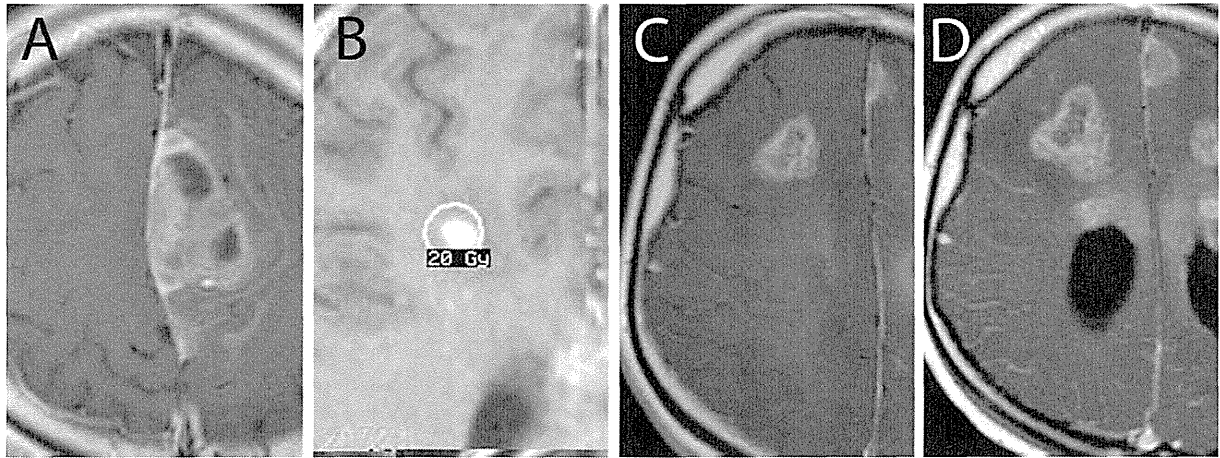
Case 7 in Table 1 is shown: (A) axial gadolinium-enhanced T1-weighted magnetic resonance imaging (MRI) at presentation; (B) dose planning of stereotactic radiosurgery for recurrence; (C, D) MRI taken at 1 (C) and 3 months (D) after stereotactic radiosurgery showing tumor progression.
